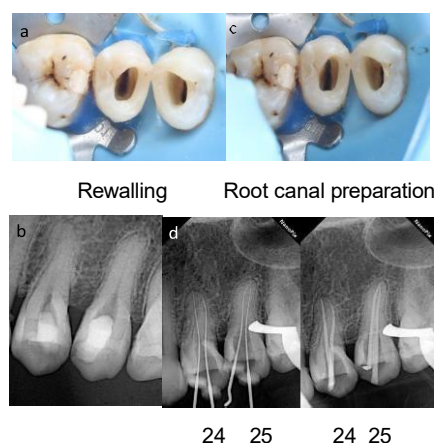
a) Rewalling of teeth 24 and 25 b) Evaluation of rewalling using periapical radiography c) Preparation of root canals of teeth 24 and 25 d) Confirmation of master apical cone (MAC).
